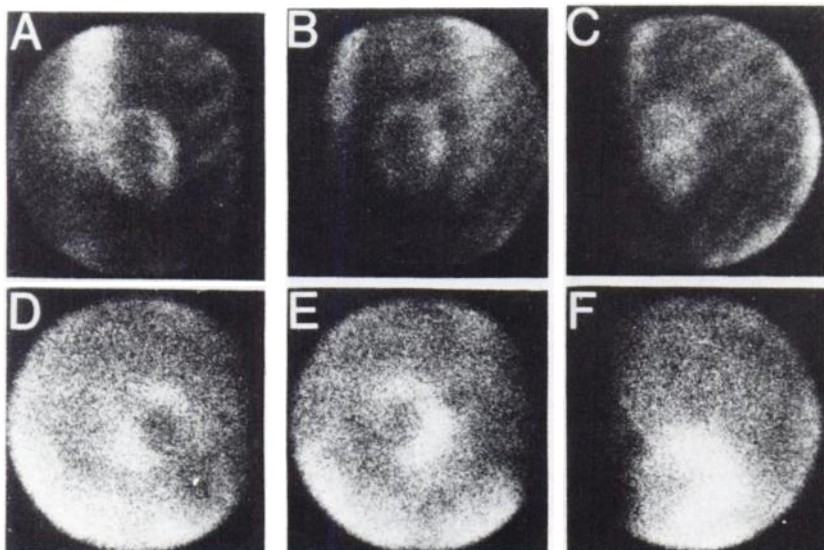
Scans of 54-year-old man (Patient No. 10) with large acute anterolateral myocardial infarction show area of abnormality to be approximately equal on $^{99m}\text{Tc-PP}_i$ and ^{201}Tl images. Parts A, B, and C represent anterior, 45° LAO, and left lateral scintigrams done 1 hr after injection of 15 mCi of $^{99m}\text{Tc-PP}_i$. Note doughnut pattern due to variability of blood flow in acutely infarcted tissue. Parts D, E, and F represent anterior, 45° LAO, and left lateral scintigrams done approximately 1 hr before $^{99m}\text{Tc-PP}_i$ scintigrams with injection of 2 mCi of ^{201}Tl . Note decreased activity in anterior and lateral myocardium.
